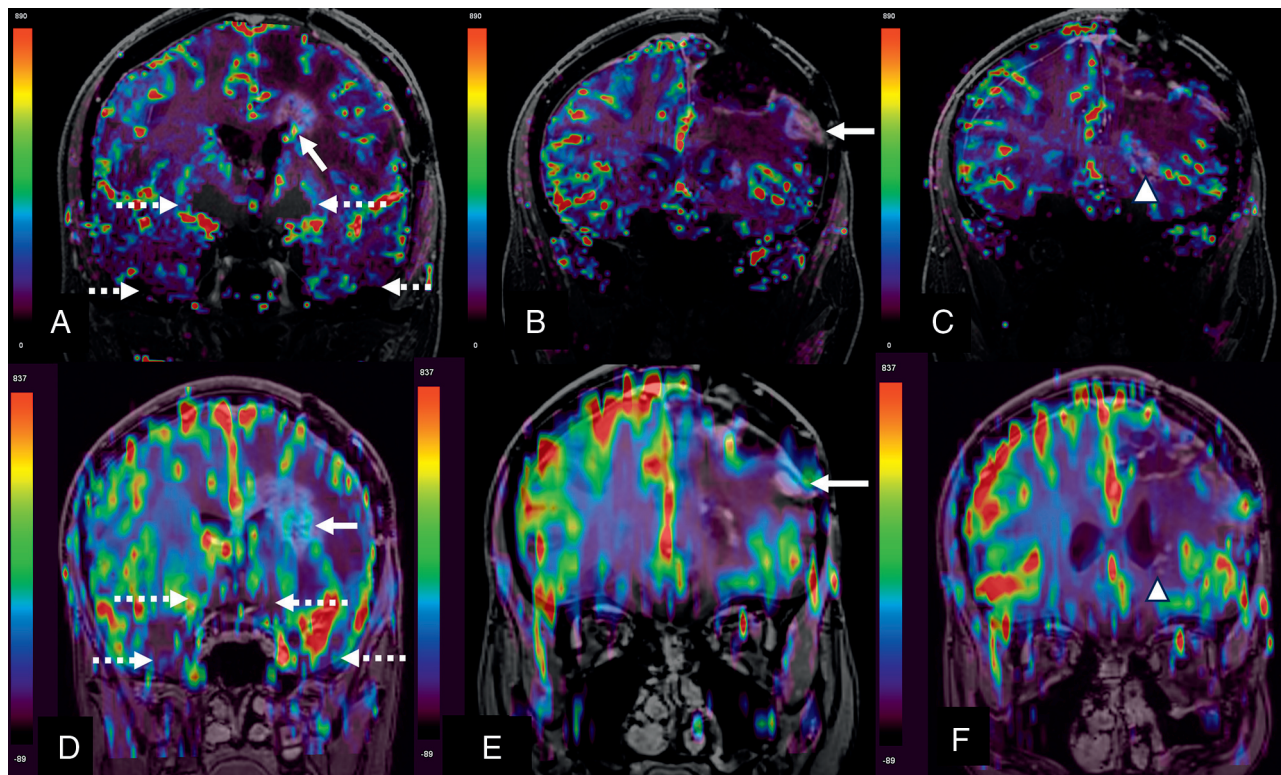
Comparison of 7T DSC perfusion MRI and 3T DSC perfusion in patient 1, a 34-year-old woman with *IDH1*-mutant, *MGMT*-promoter-methylated World Health Organization grade 4 astrocytoma, status postsurgical debulking, radiation therapy, and chemotherapy with temozolomide and lomustine. Coronal reconstructions of 7T fused CBV map with contrast-enhanced 3D TI-MPRAGE are shown (A–C). D–F, show coronal reconstructions of 3T fused CBV map with contrast-enhanced 3D TI-MPRAGE, obtained 5 months later. A, *Solid arrow* depicts an enhancing periventricular lesion posterior and inferior to the surgical cavity with visually increased rCBV in the inferior enhancing component ($rCBV_{\max} = 237$), designated as tumor progression visually by the neuroradiologists. *Dashed arrows* represent susceptibility-related low signals near the skull base. B, *Solid arrow* shows enhancement in the inferior aspect of the resection margins without visually increased rCBV ($rCBV_{\max} = 137$), designated as treatment effect. C, *Arrowhead* points to a new enhancing nodular focus in the ventral periventricular white matter, demonstrating similar contrast enhancement to the lesion in (A), with questionable visually increased rCBV ($rCBV_{\max} = 188$). Although perfusion findings were not highly suspicious, because of new occurrence and nodularity, radiologists defined this lesion as indeterminate. (contralateral corona radiata $rCBV_{\max} = 63$, contralateral frontal cortex $rCBV_{\max} = 346$) D, *Solid arrow* represents progression of lesion seen in (A) with increased size and visually increased internal perfusion. This lesion was biopsied and confirmed as tumor progression. *Dashed arrows* represent increased susceptibility-related low signal near the skull base, still present at 3T but less conspicuous compared with 7T. Significant staircase artifacts are present at 3T coronal maps compared with 7T, with false increased perfusion superimposed on calvaria. E, *Solid arrow* depicts decreased size of enhancing lesion inferior to the resection cavity without visible increased rCBV, corresponding to the *solid arrow* in (B), confirming treatment effect. F, *Arrowhead* depicts decreased size of enhancing lesion in (C) without any visibly increased rCBV, confirming treatment effect.
